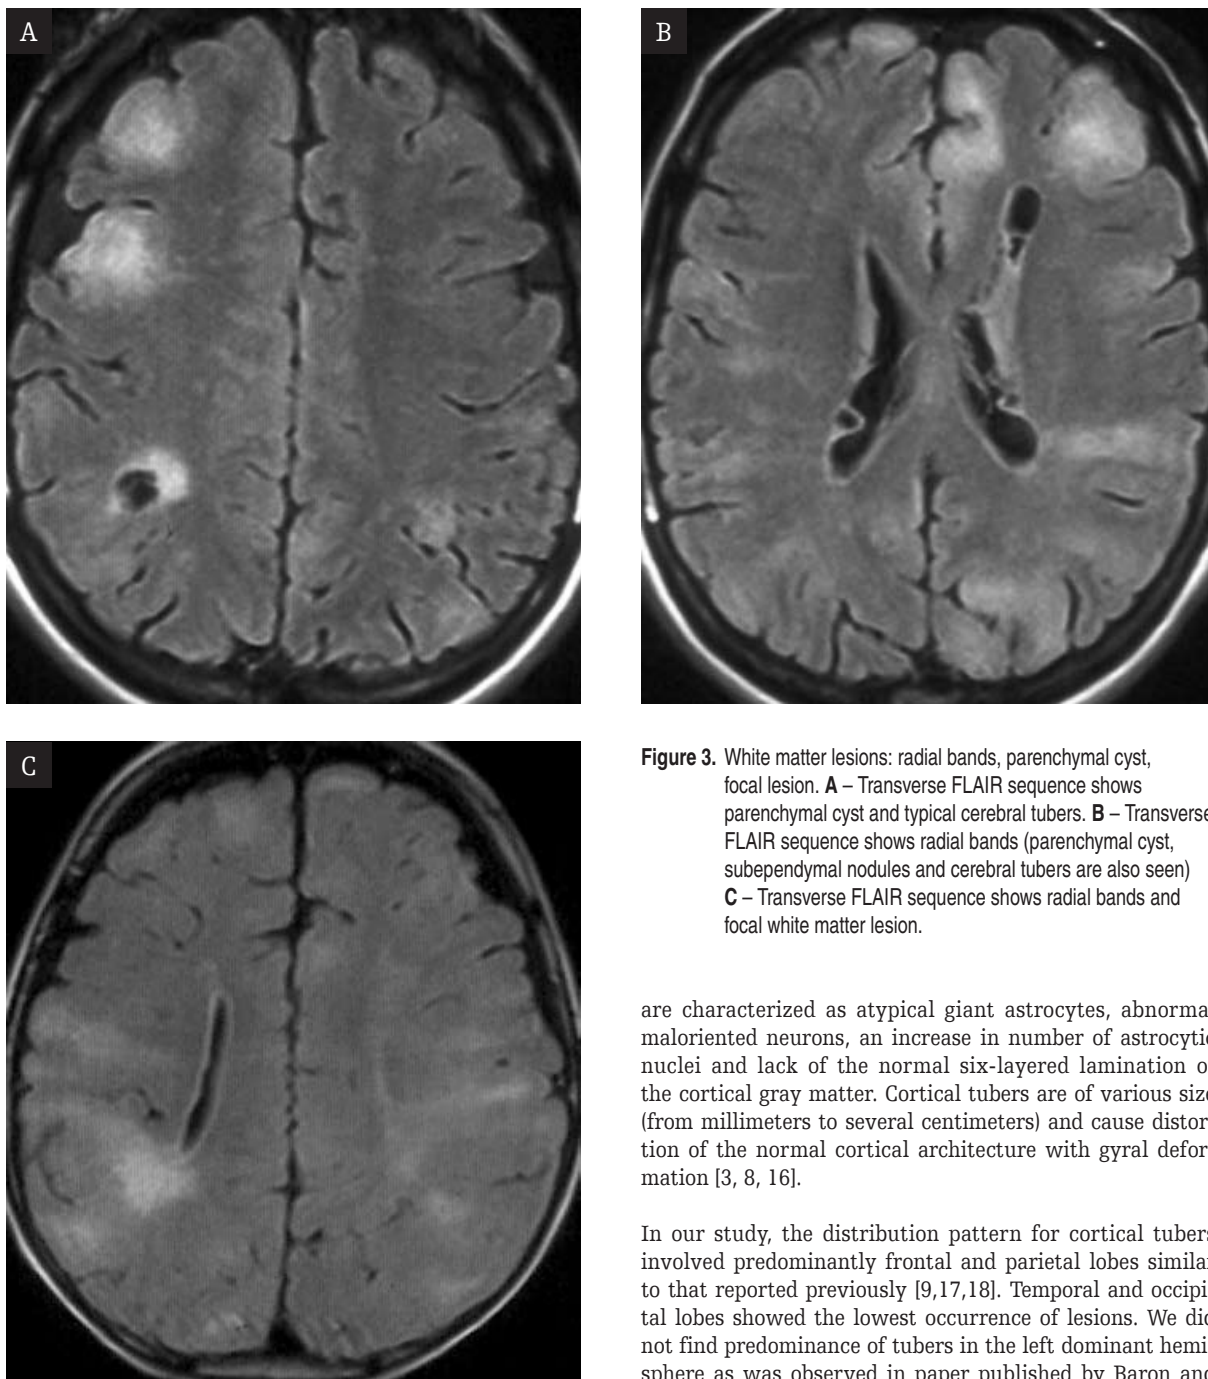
White matter lesions: radial bands, parenchymal cyst, focal lesion. A – Transverse FLAIR sequence shows parenchymal cyst and typical cerebral tubers. B – Transverse FLAIR sequence shows radial bands (parenchymal cyst, subependymal nodules and cerebral tubers are also seen) C – Transverse FLAIR sequence shows radial bands and focal white matter lesion.
